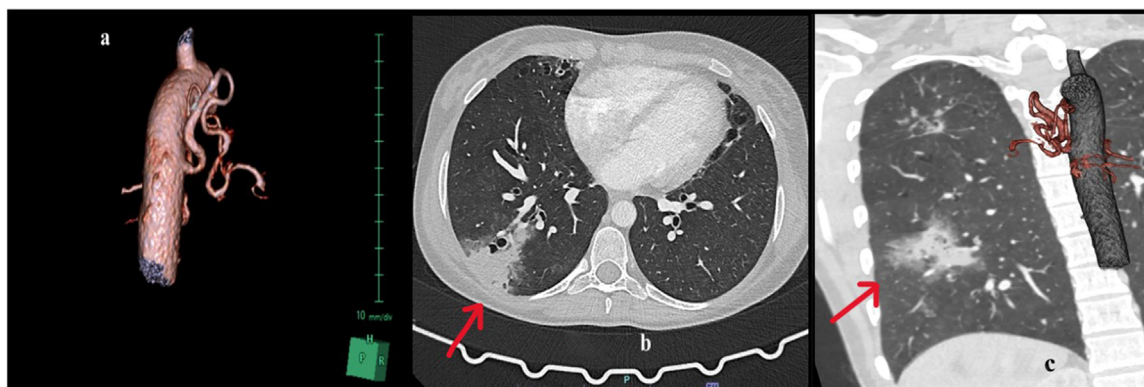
(a) 3D angio CT reconstruction of the right hypertrophic bronchial artery emerging from the descending aorta; (b) Axial CT image of parenchymal consolidation in the superior segment of the right lower lobe; (c) 3D angio CT reconstruction of the right hypertrophic bronchial artery and coronal CT section of the right lower lobe parenchymal consolidation.
